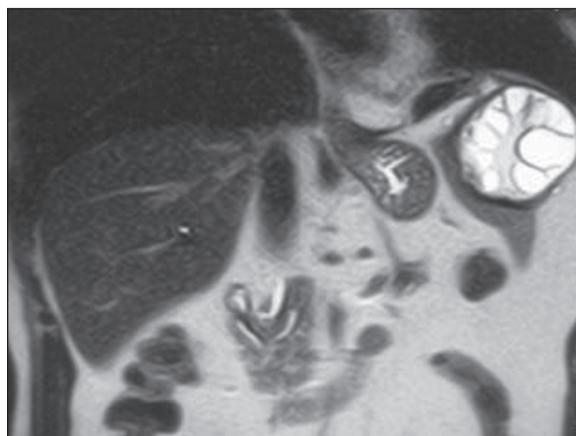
Left-sided infradiaphragmatic cystic lesion on the magnetic resonance imaging consistent with hydatid disease.
